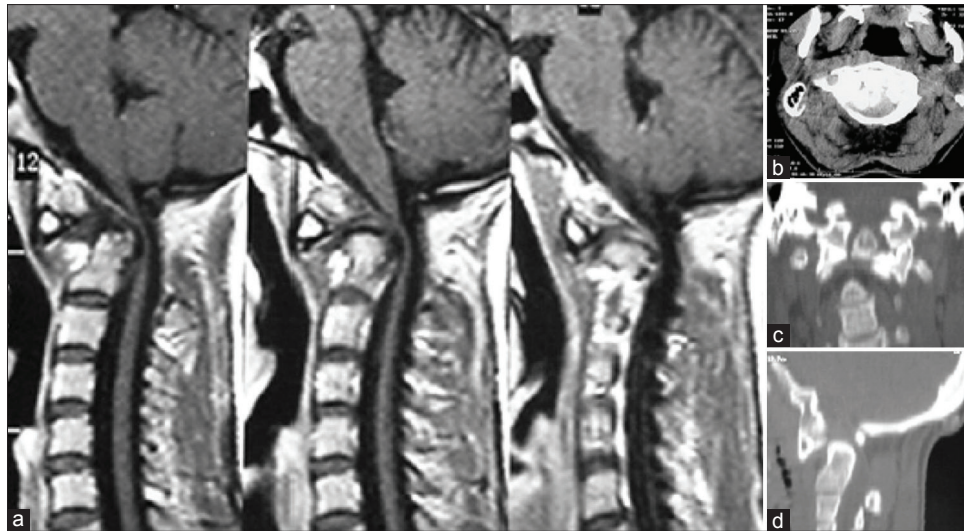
The patient with a C2 type III fracture presented with symptoms of upper spinal cord compression. (a) Sagittal T2 weighted magnetic resonance imaging scans depicted C2 fracture and spinal cord compression at the same level. (b) Axial computed tomography scan depicted bone fragments into the spinal canal with spinal cord compression. (c) Coronal reconstruction of the computed tomography scans depicted C1–C2 dislocation and C2 Type III fracture. (d) Sagittal reconstruction of the computed tomography scans depicted C1–C2 dislocation
